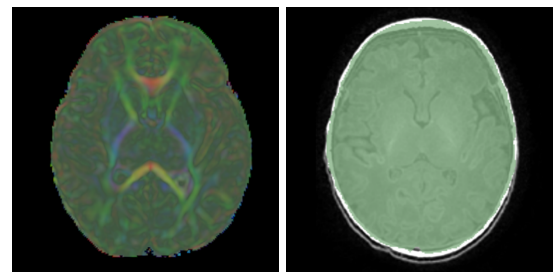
Left is the DTI mask generated automatically; right is the T1 MRI mask generated manually.
